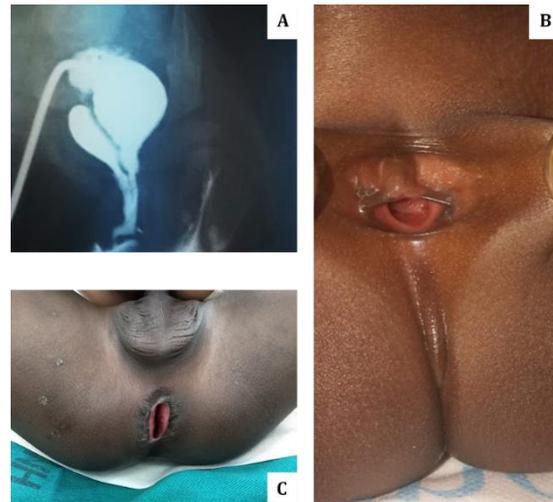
Contrast study of one of the patients with cloacal anomaly, Note the absence of Mullerian remnants a rare variant of the anomaly. Fig 3B: Perineal examination of the patient in fig 3A above. Note the single perineal opening suggestive of cloacal anomaly. Fig 3C: Neo-anus of a patient with multiple surgeries presenting with stool incontinence. An MRI reported an ectopic neo-anus with good sphincter capacity
